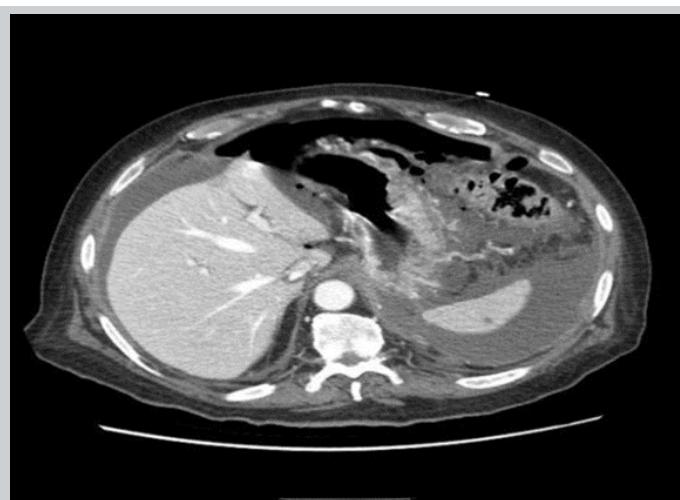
CT abdomen with IV contrast showed pneumoperitoneum, free fluid suggestive of perforated viscus.
